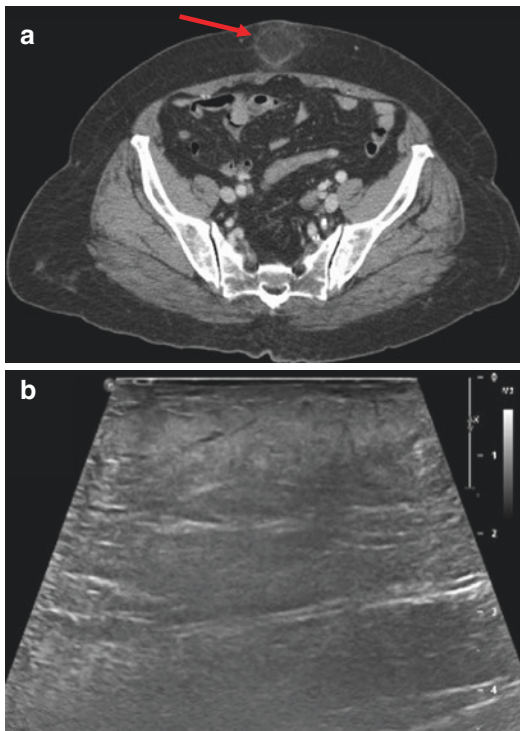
Fat necrosis. Axial contrast-enhanced CT (a) scan of an abdomen shows a hypodense lesion in the subcutaneous tissue. Rim enhancement (*arrow*) and perilesional stranding can be seen. US (b) shows a hyperechoic, heterogeneous poorly defined region
